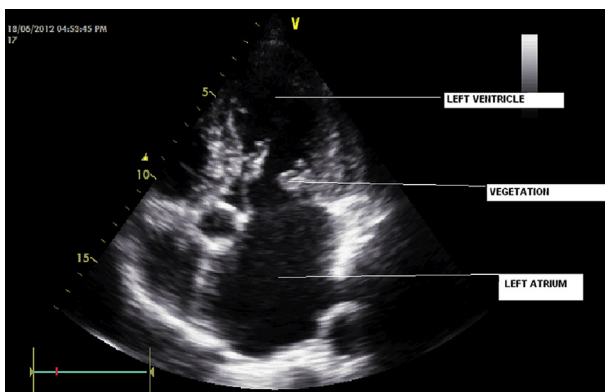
Echocardiogram picture showing vegetations.
